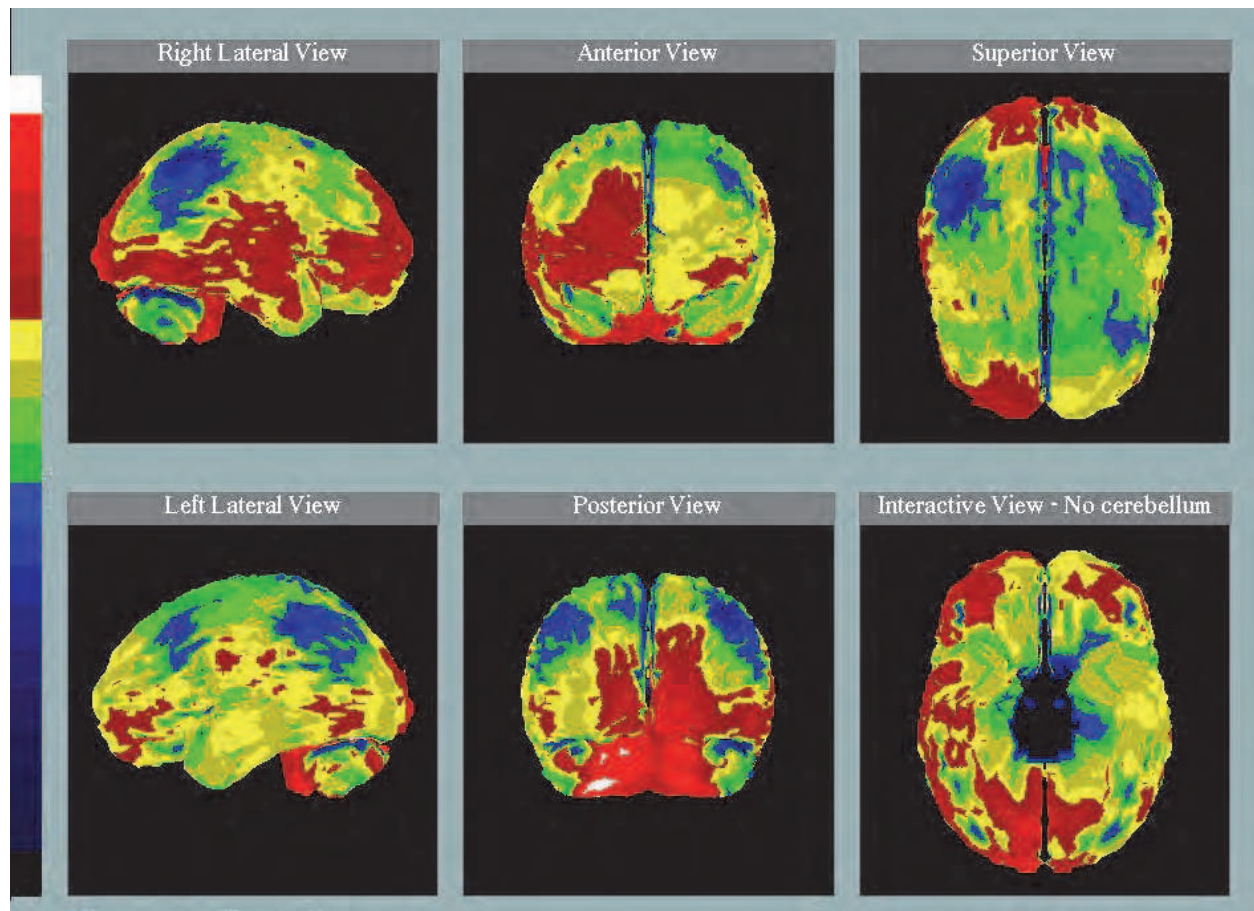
Brain perfusion SPECT study in a patient with Alzheimer's disease. Reduced  $^{99m}\text{Tc}$ -HMPAO uptake in parietal, temporal and frontal lobes. Hypoperfusion is more severe on the left hemisphere.
